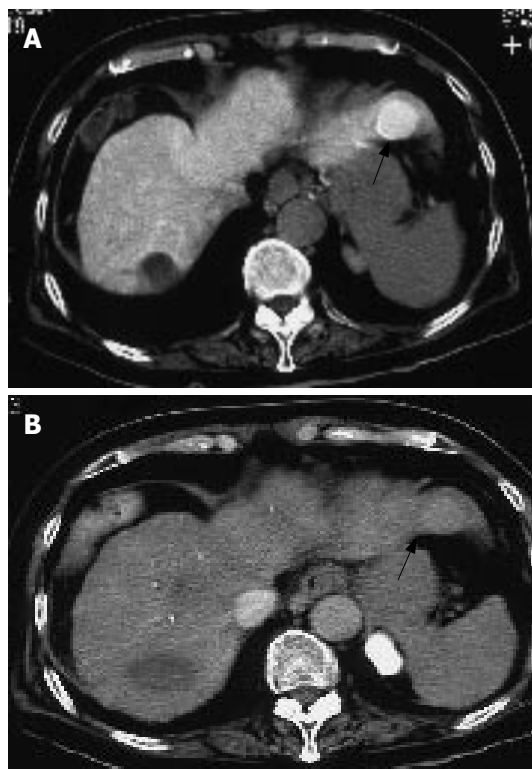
A: Hyperattenuation in S2 on computed tomography during arteriography (CTA); B: Hyperattenuation in S2 on computed tomography during arterial portography (CTAP).
